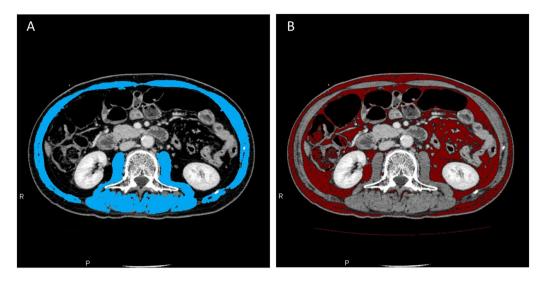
Cross-sectional computed tomographic images of the middle portion of the 3rd lumbar vertebra level. (A) Skeletal muscle area was measured using manual tracing. (B) After applying threshold with an attenuation range of -60 to -120 Hounsfield units to generate a fat-density mask, the fat area was measured in the region of interest.
